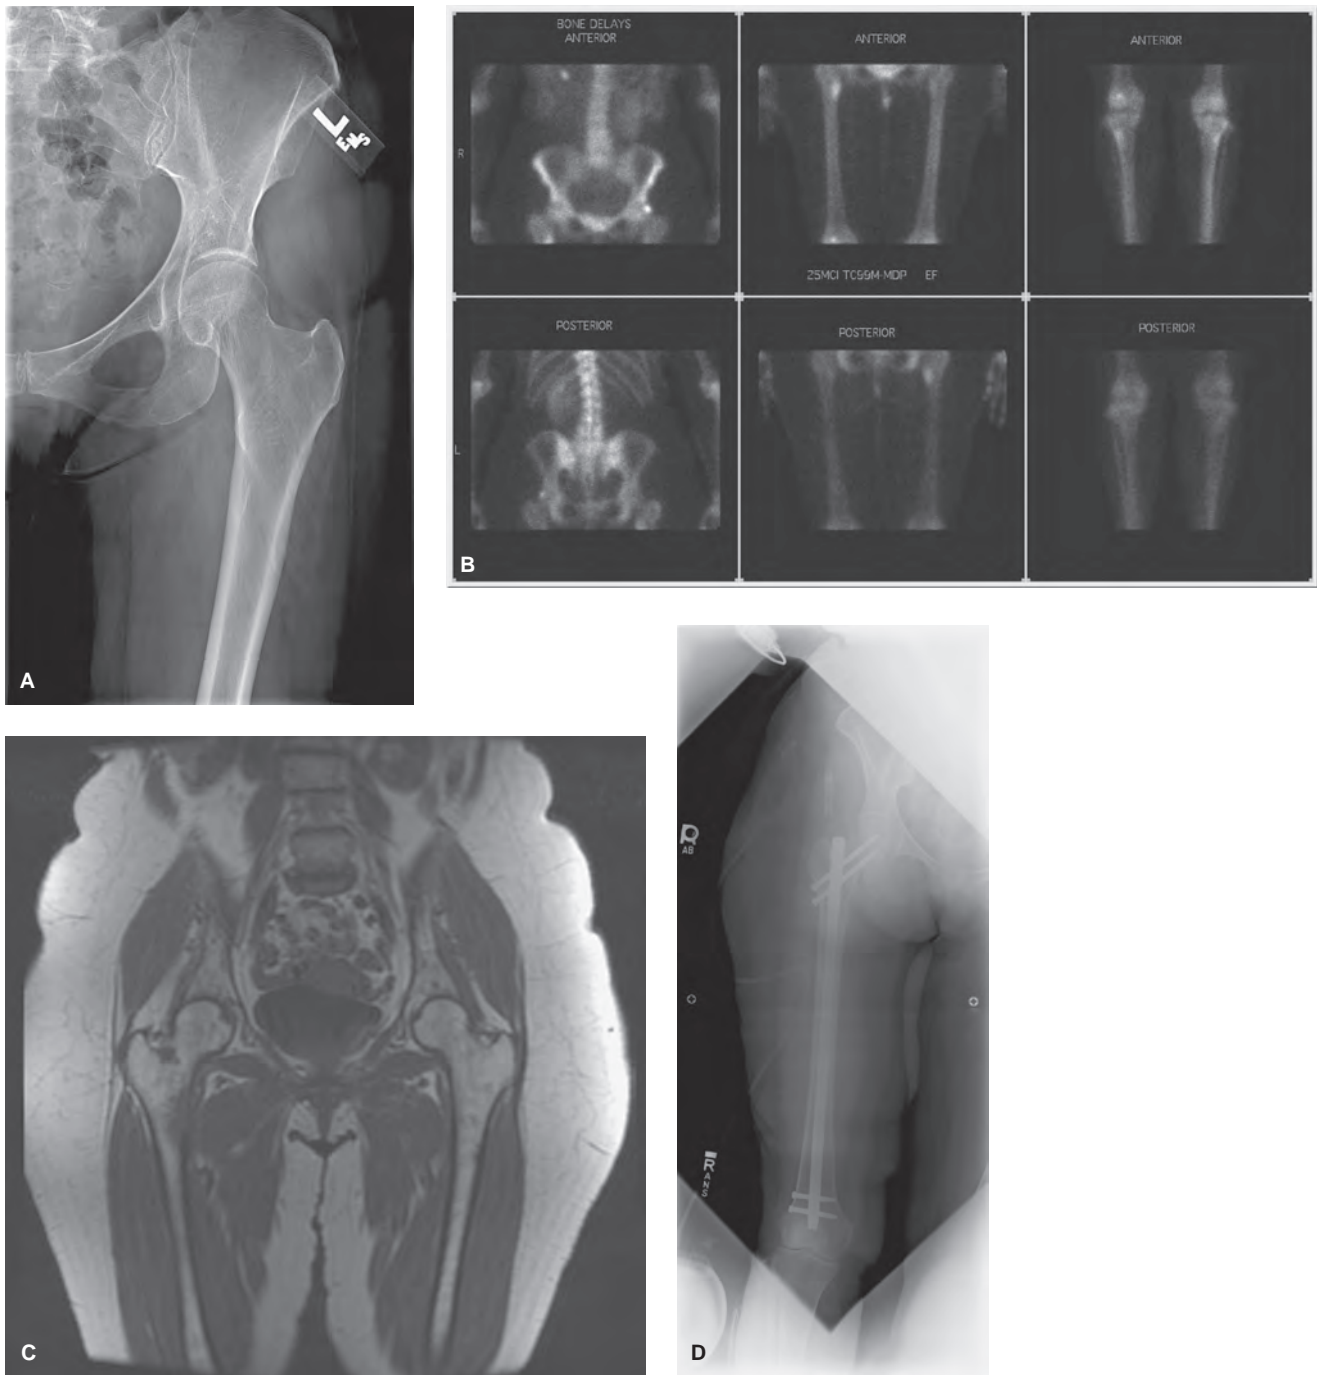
(A) Anteroposterior proximal femur in 56-year-old woman with 2-month history of increasing weightbearing pain in the femur and a history of breast cancer treated 1 year previously. Lytic destructive disease present extending from trochanter to proximal shaft. (B) Tc-94m methylene-diphosphonate (MDP) scan shows uptake in proximal right femur subtrochanteric region. (C) Coronal T1-weighted magnetic resonance image shows marrow replacement of proximal shaft of femur as well as other lesions in ilium. (D) Anteroposterior femur plain radiograph following intermedullary nailing of the femur. Percutaneous biopsy prior to nail placement confirmed metastatic breast cancer. Patient resumed ambulation without pain.
